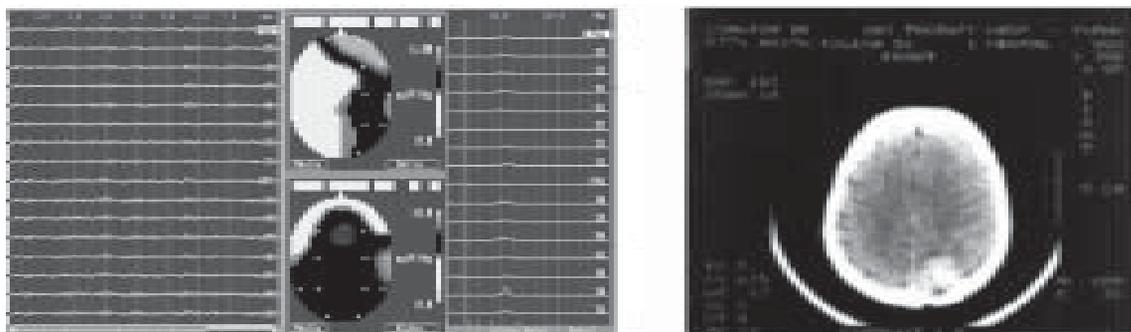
EEG and CT-scan (recurrent tumor mass in right occipital region) 10 months later.
